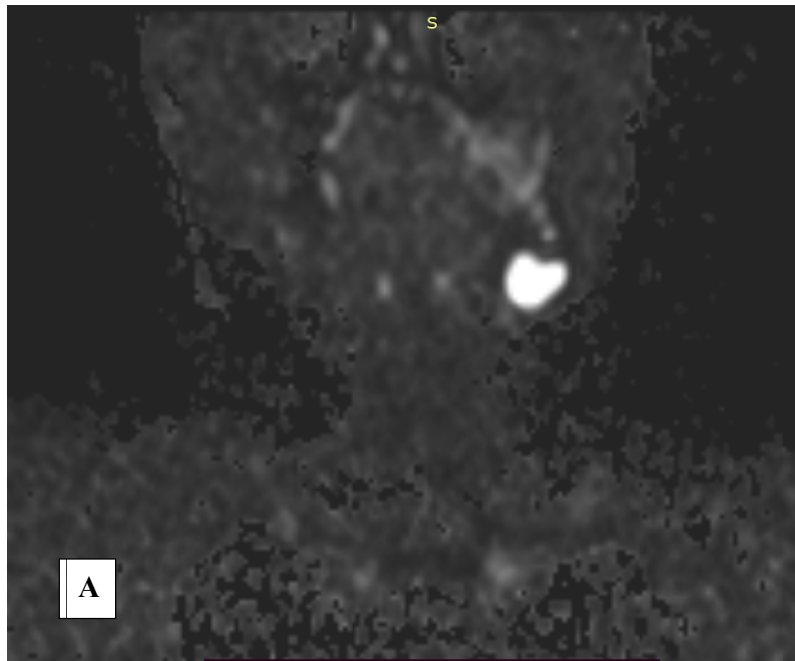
DWI image showing margins of lymph nodes
